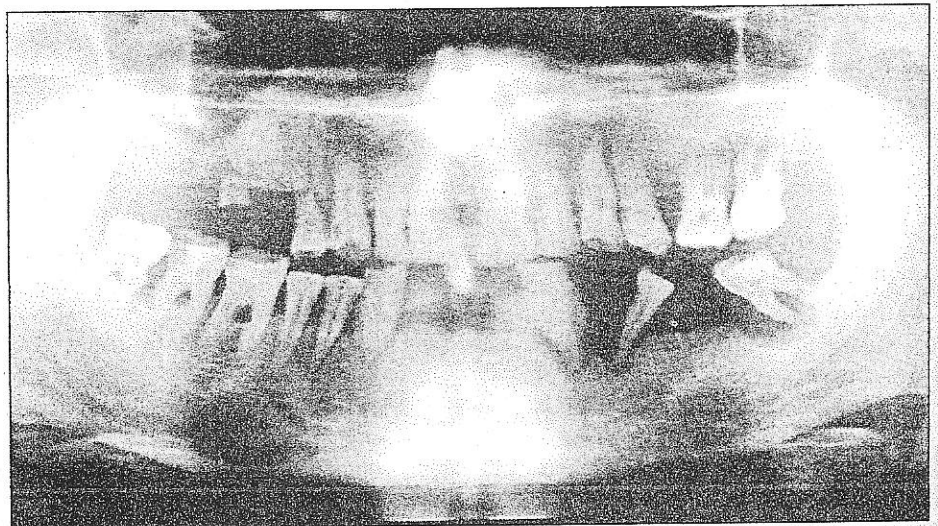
Panoramic radiograph disclosing marginal bone loss of the involved teeth.
